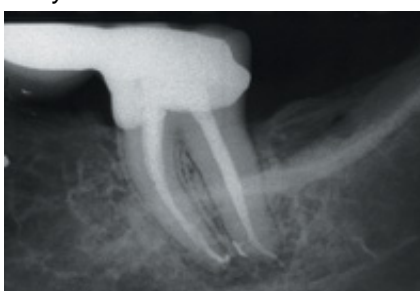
A 6-month postoperative radiograph demonstrating normal level of alveolar bone.
